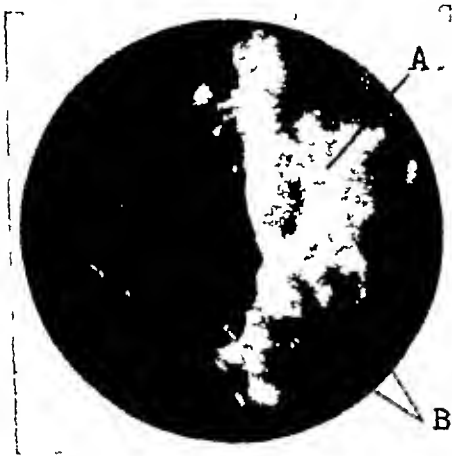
A patient whose roentgen examination showed spastic folds. At A, we see the photographic appearance of such a fold, at B the ulcers, confirming the assumption based on the roentgen evidence.
